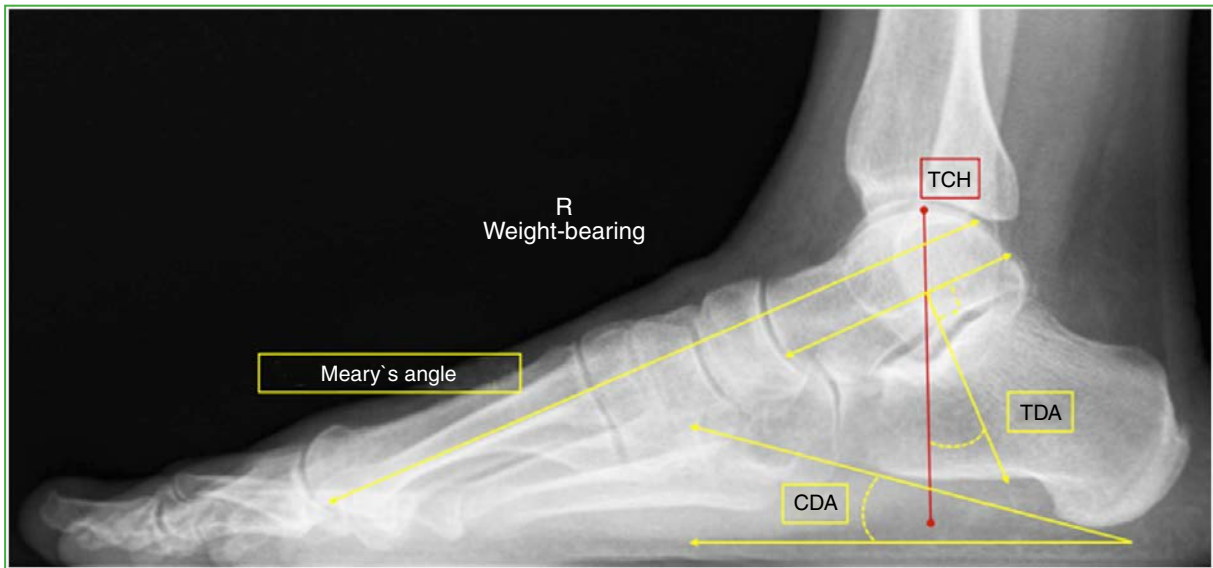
Measurements obtained on a weight-bearing lateral radiograph of an uninjured foot. TCH = talocalcaneal height; TDA = talar declination angle; CDA = calcaneal declination angle.
